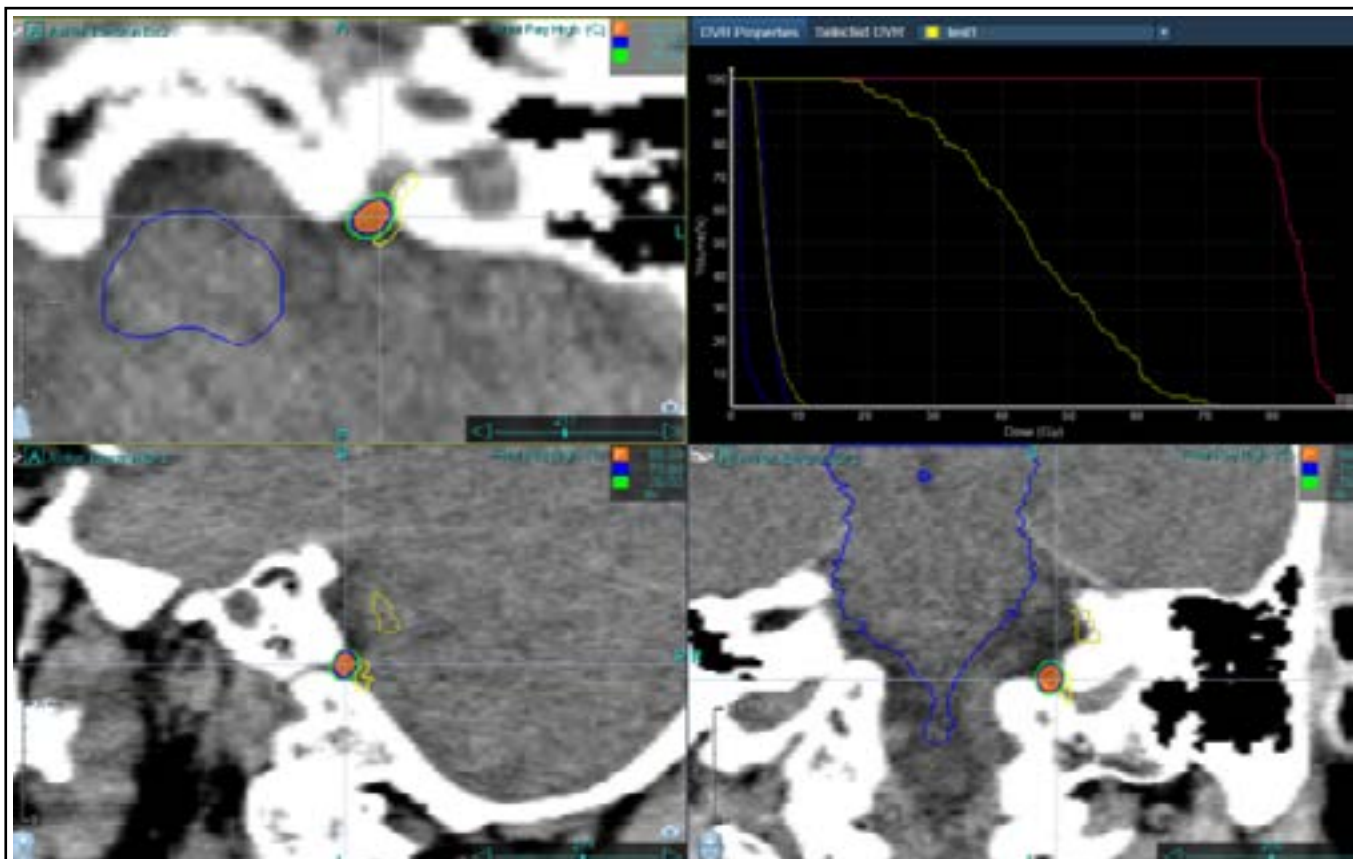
Upper left: Proximity of the target volume (Left glossopharyngeal meatus) depicted in red and the avoidance structure (vagus nerve shown in yellow) showing relationship with brainstem (dark blue). Upper right, Dose Volume histogram showing target volume coverage. Lower left and right: Sagittal and coronal CT images of target volume.
